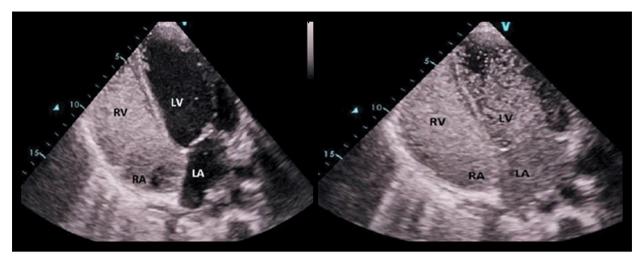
Agitated saline echocardiography (Bubble study) elucidating the microbubbles and delayed opacification of left atrium.
